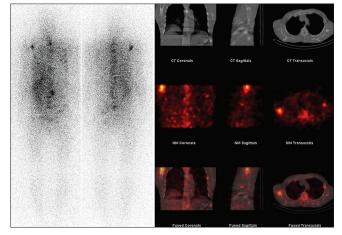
A 50-year-old male with hypertension and bony pains was referred for metaiodobenzyl guanidine (MIBG) study. Iodine-131 MIBG study with single photon emission computed tomography (SPECT)/Computerized tomography (CT) revealed MIBG avid lesions in the para-vertebral region and multiple vertebrae. SPECT/CT showed multiple areas of lytic changes in the visualized bones indicating widely metastastic pheochromocytoma. The patient was subjected to chemotherapy and had partial symptomatic relief
